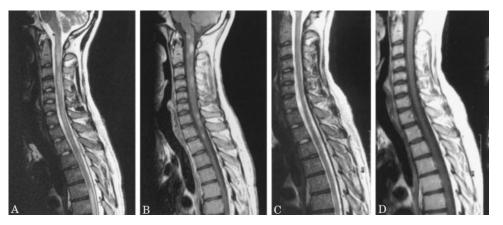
Sagittal T2- and T1-weighted fast spin echo images of the cervical and upper thoracic spine reveal multiple contrast-enhancing intramedullary lesions (A, B). Follow-up MRI after 6 weeks of treatment demonstrates blurring of the lesions on T2-weighted images (C) and regression of contrast enhancement on T1-weighted images (D).
